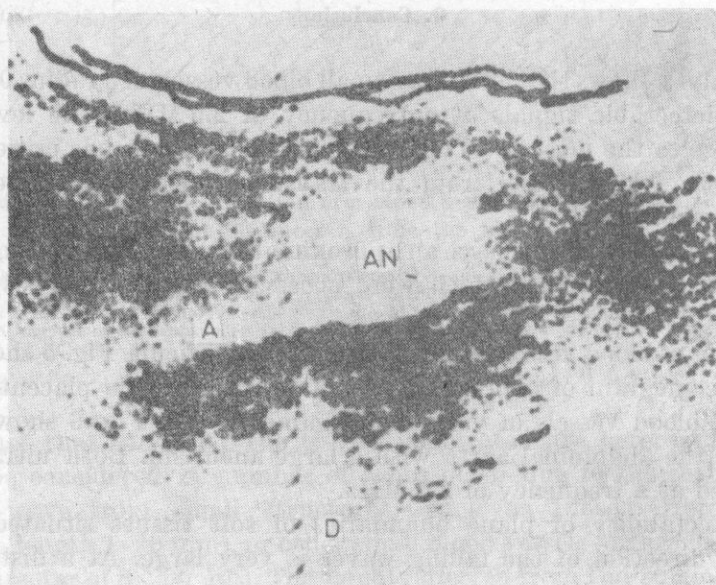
An ultrasonogram of the abdominal aorta *A*, obtained with the USG-10 apparatus [2]
